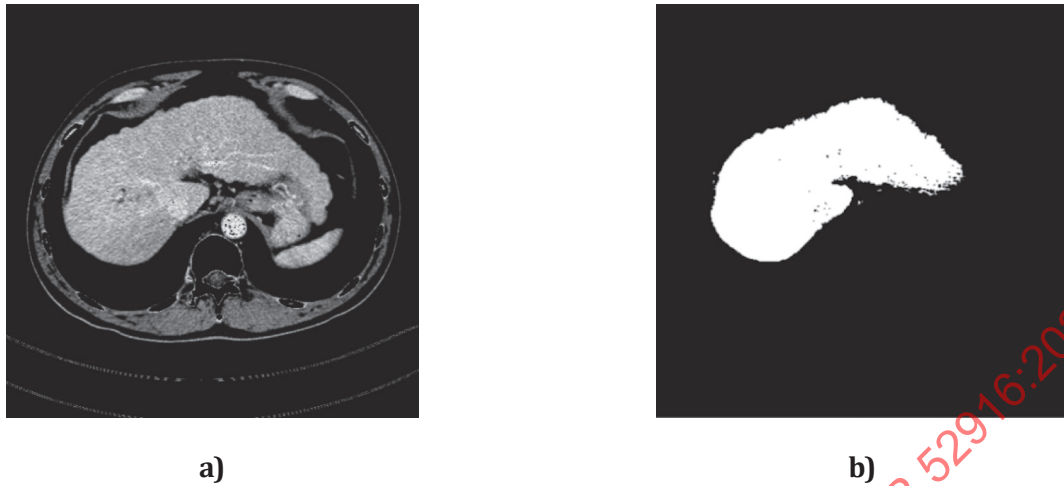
Soft tissue segmentation a) CT image b) Liver region of CT image
